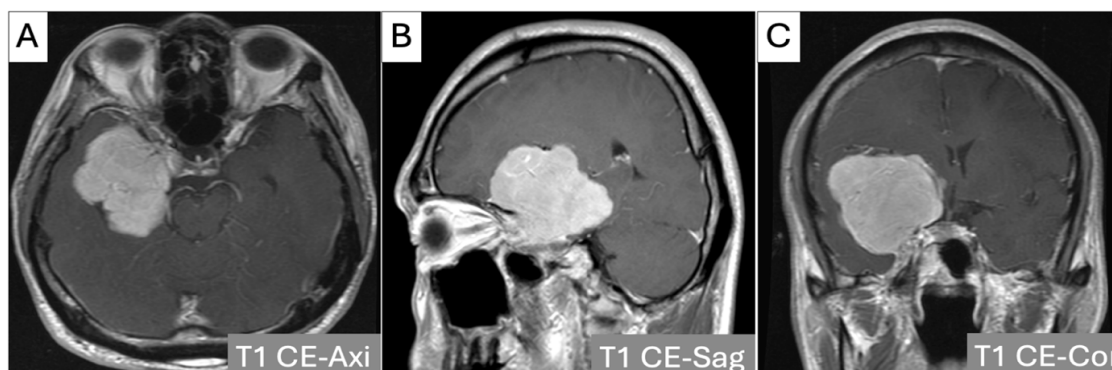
Brain MRI with contrast injection with T1W on the axial plane (Fig 1A.), sagittal plane (Fig 1B) and coronal plane (Fig 1C) reveals a 6x5.4cm tumor with most contrast-enhanced and well-defined with compression of the brainstem and lateral ventricles, third ventricle.
